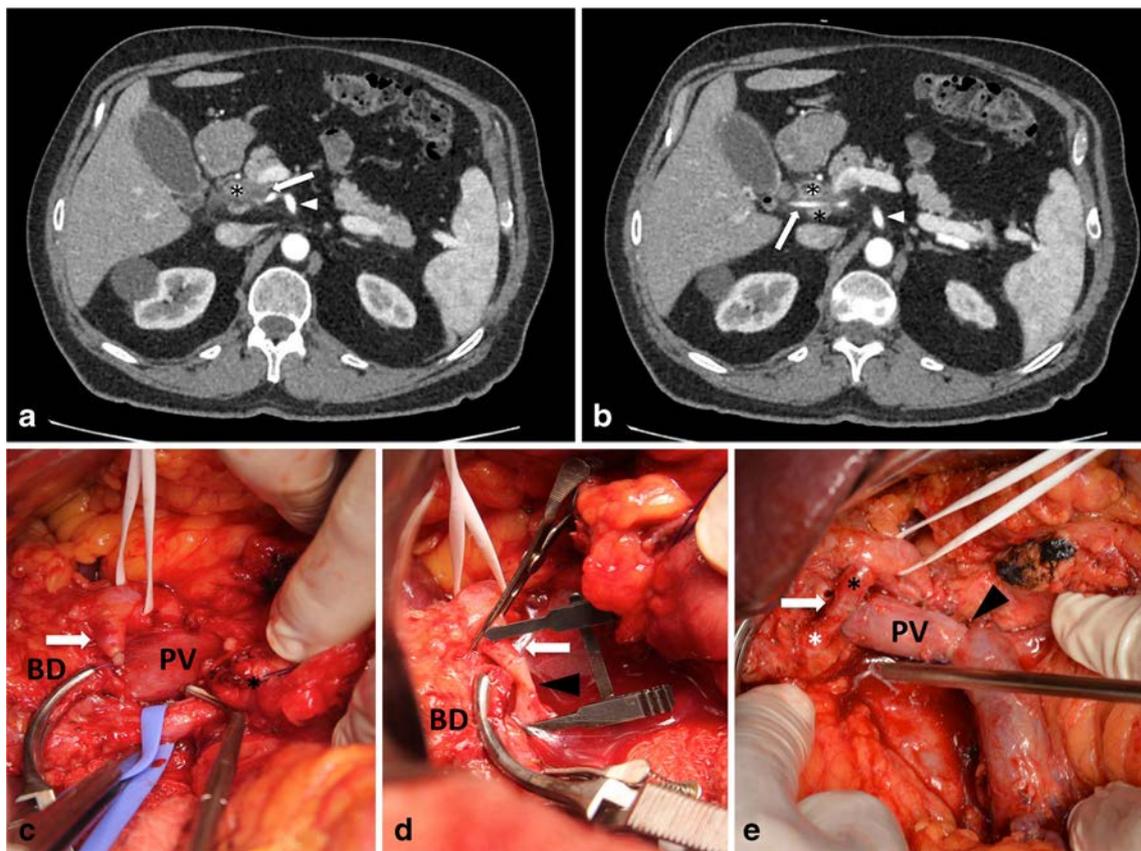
a,b Multislice CT scan showing circumferential tumor involvement (*asterisk*) of a replaced right hepatic artery (*white arrow*) originating from the superior mesenteric artery (*white arrowhead*). c Intraoperative confirmation of aberrant right hepatic artery (encircled with a blue vessel loop) with tumor involvement (*asterisk*). The *white arrow* shows the gastroduodenal artery stump. d Microvascular end-to-end anastomosis between the gastroduodenal artery stump (*white arrow*)
